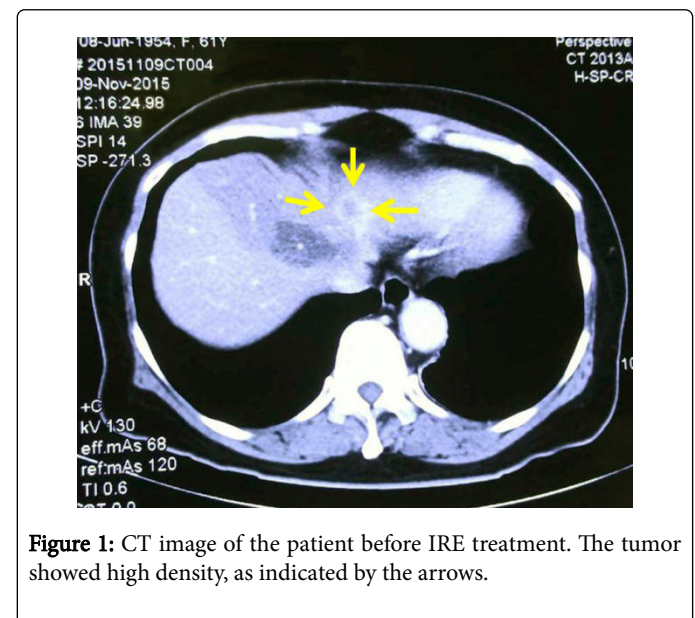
CT image of the patient before IRE treatment. The tumor showed high density, as indicated by the arrows.
